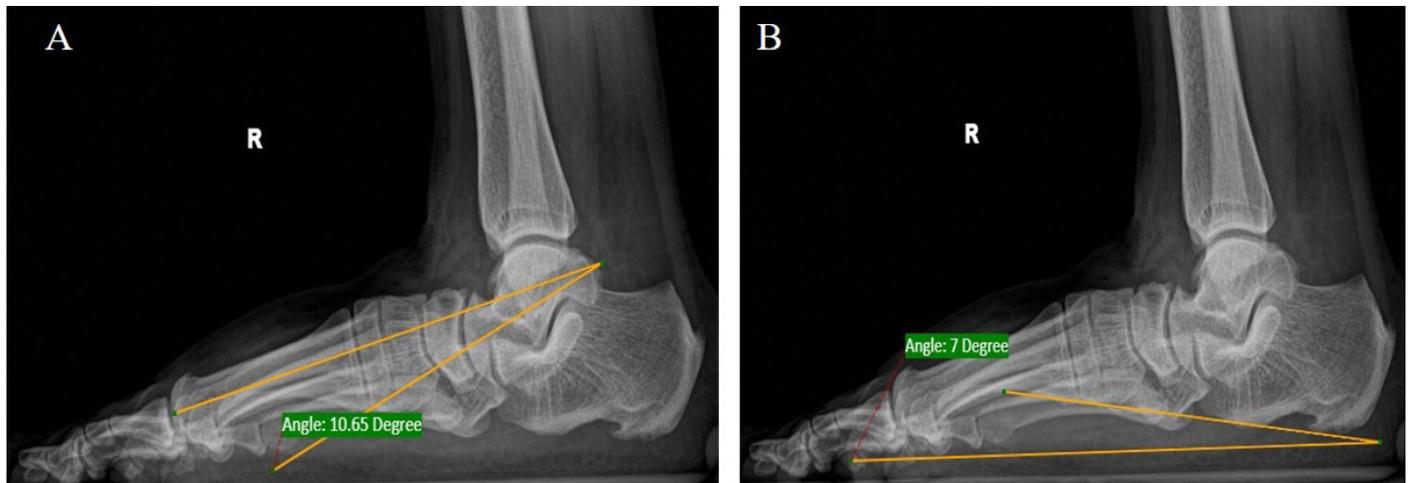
Radiographs showing the adult acquired flat foot deformity. A. Meary's angle is disturbed (10.65°, normal range 0-49). B. Calcaneal pitch angle is decreased (7°, normal range 20-40°), indicating the collapse of the medial longitudinal arch.
